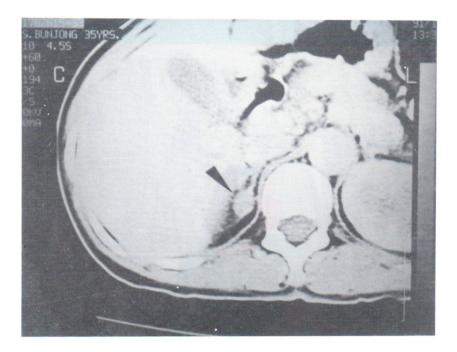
A 35-year-old woman with hypertension and hypokalemia. Contrast enhancement, 5 mm-thick CT section shows homogeneous low-attenuation right adrenal nodule (arrow head).
